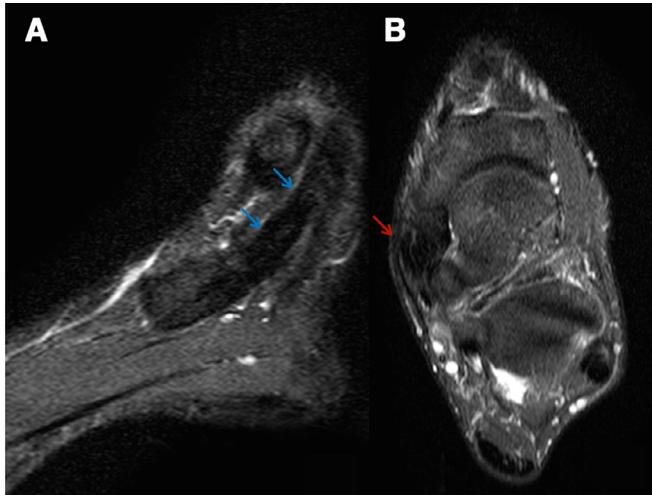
Magnetic resonance images of the posterior tibial tendon (PTT) obtained 1 year after surgery. (A) Sagittal short tau inversion recovery image shows the PTT to be intact and continuous (blue arrow). (B) Axial short tau inversion recovery image shows a residual linear minimally hyperintense signal in the distal segment of the PTT just before its insertion. This hyperintensity is most likely related to the suture site (red arrow). There is no evidence of tenosynovitis.
